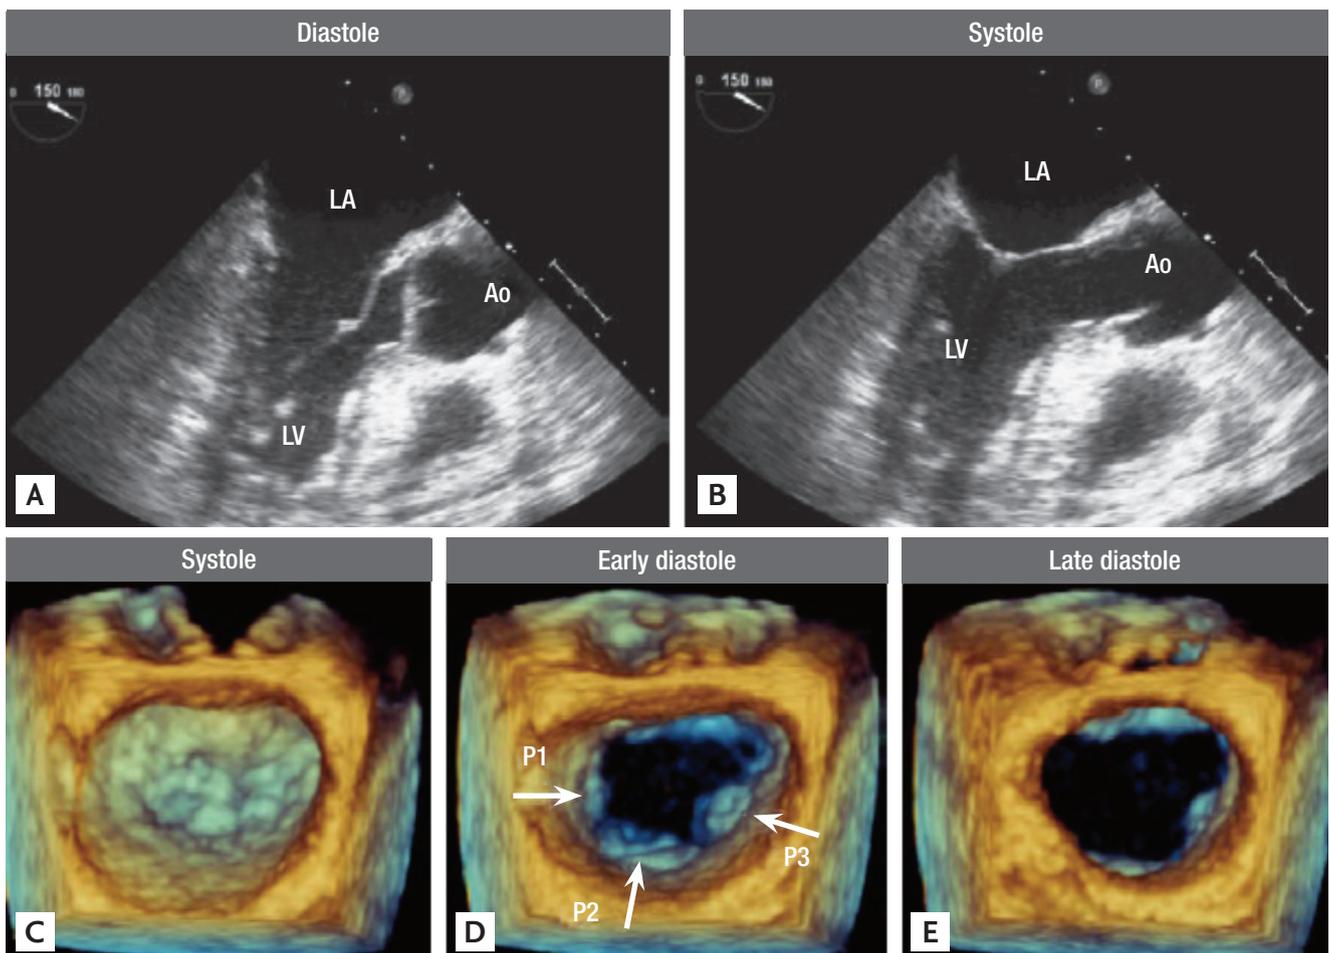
Normal mitral valve imaged by 2-dimensional (D) echo (A, a long axis view in diastole; B, in systole) and real-time 3D transesophageal echocardiography (C, a view from the left atrium in systole; D, in eerily diastole; E, in late diastole). Arrows indicate each leaflet: lateral P₁, middle P₂, and medial P₃. Ao, aorta; LA, left atrium; LV, left ventricle.
